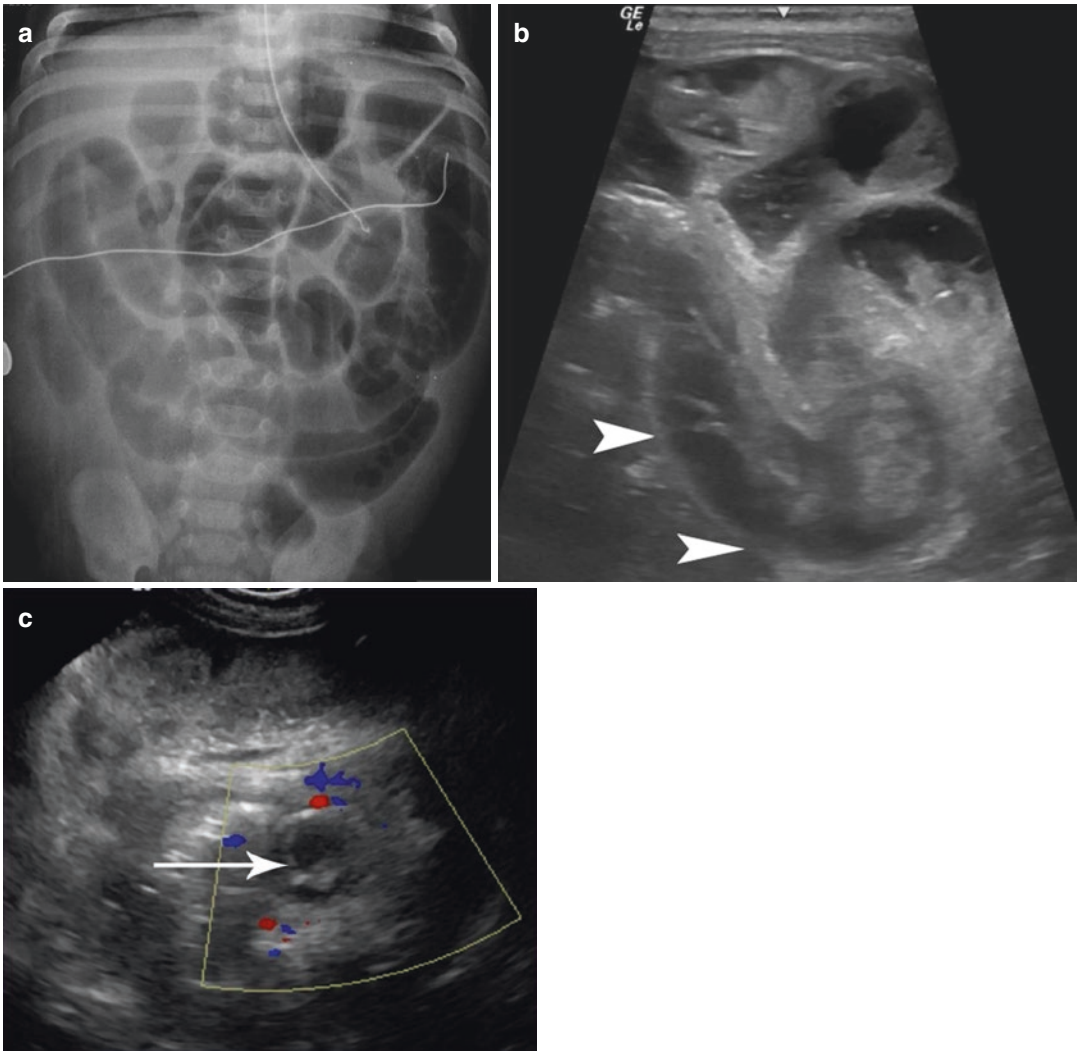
Meckel diverticulum: (a) Frontal view of an abdomen X-ray showing intestinal dilated loops. (b) Transverse US scan showing intestinal dilated loops
